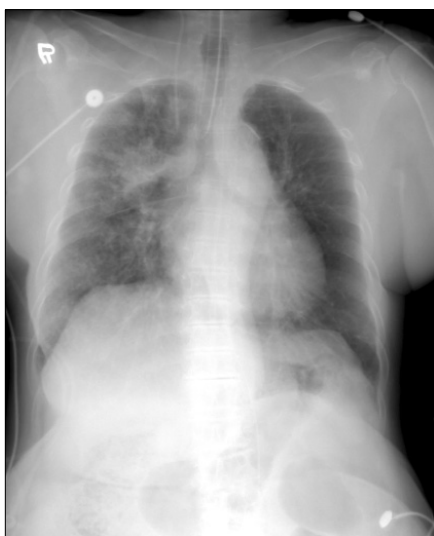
The chest radiography showed consolidation combined with linear opacity on right upper lobe.
